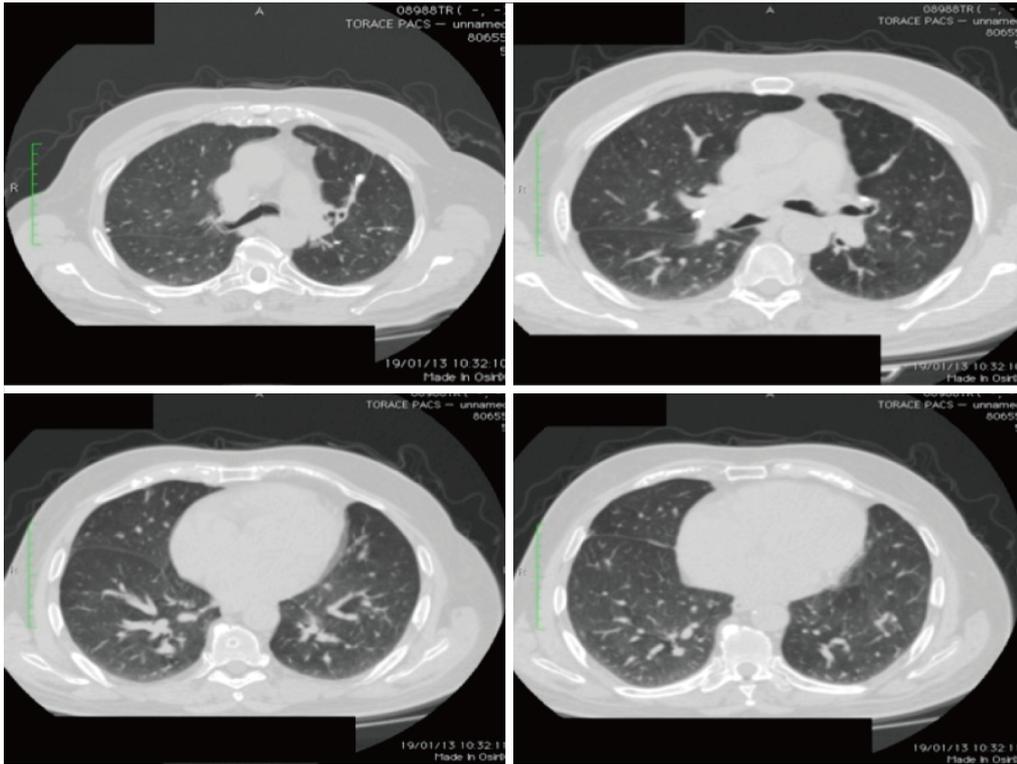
Thorax computed tomography-scan showing the complete response after discontinuing bevacizumab (January 2013).
